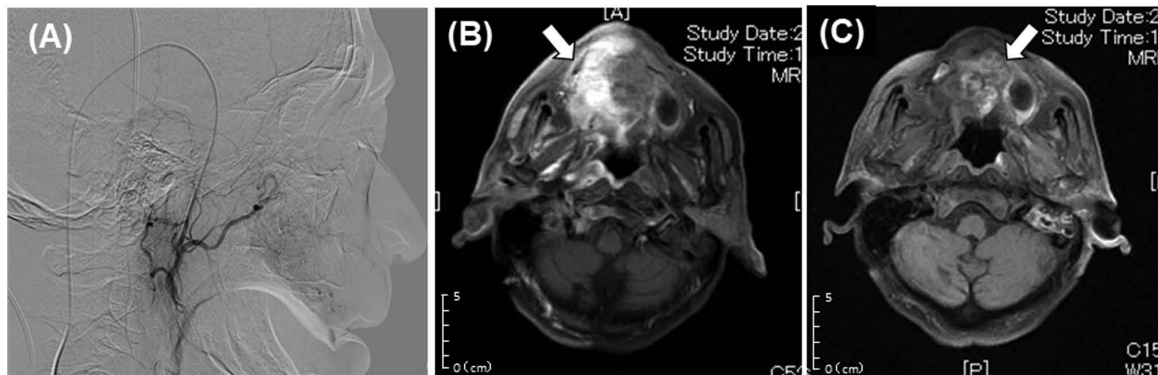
Flow check for the delivery of anticancer agents by contrast-enhanced T1-weighted axial magnetic resonance imaging. (A) Flow check by digital subtraction angiography using contrast medium. Flow check by enhanced magnetic resonance imaging via a catheter to cover the whole tumor; (B) the right side of the maxilla is highly enhanced (arrow), whereas (C) the left side is enhanced slightly (arrow).
